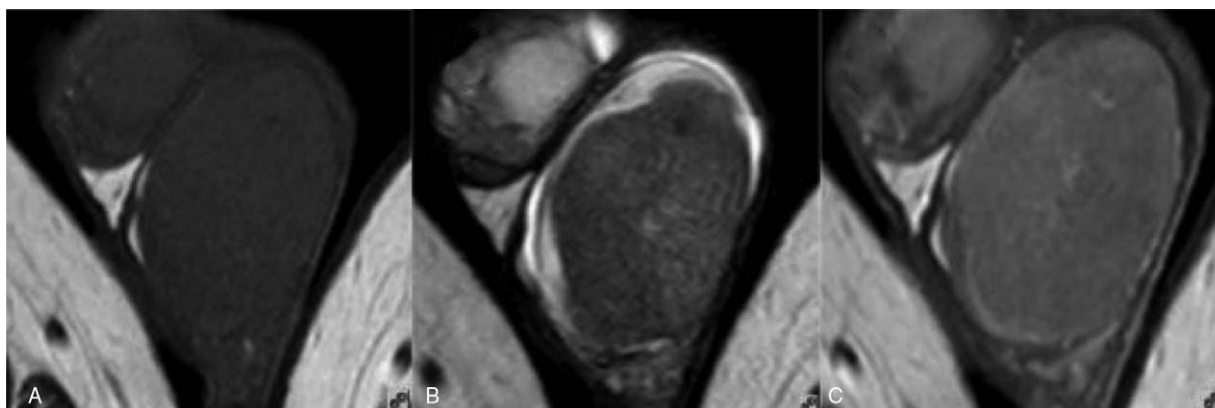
Forty-two-year-old male with seminoma of the left testicle. (A) Transverse T1WI showing left testicular enlargement and a uniform isointense signal; (B) transverse T2WI showing a hypointense tumor that comprised a single mass with shallow lobulation, the size of the tumor was 5.9 cm × 6.6 cm × 5.7 cm; and (C) transverse T1WI+CE showing a slightly enhanced tumor with no enhancement of the fibrous septa and an internal arterial blood supply. CE=contrast enhancement, T1WI=T1-weighted imaging, T2WI=T2-weighted imaging.
